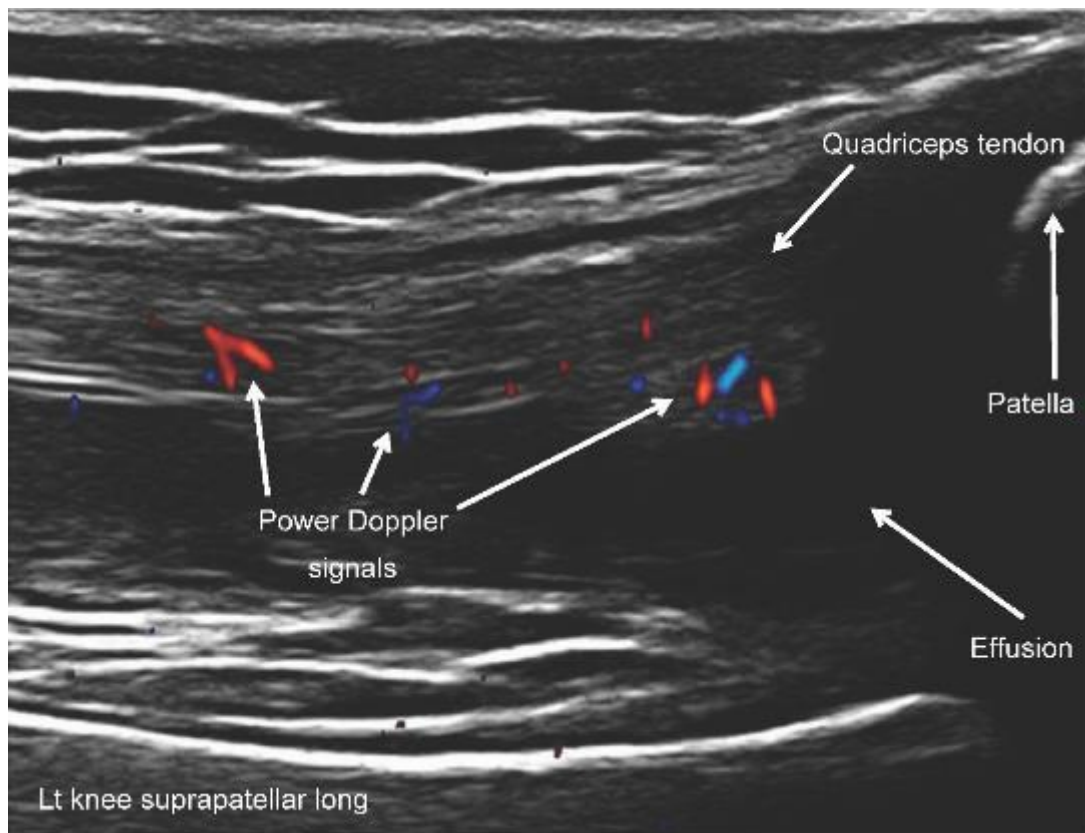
Increased bidirectional Power Doppler signals in the suprapatellar fat pad and quadriceps tendon around the suprapatellar recess in a longitudinal scan on sagittal plane
